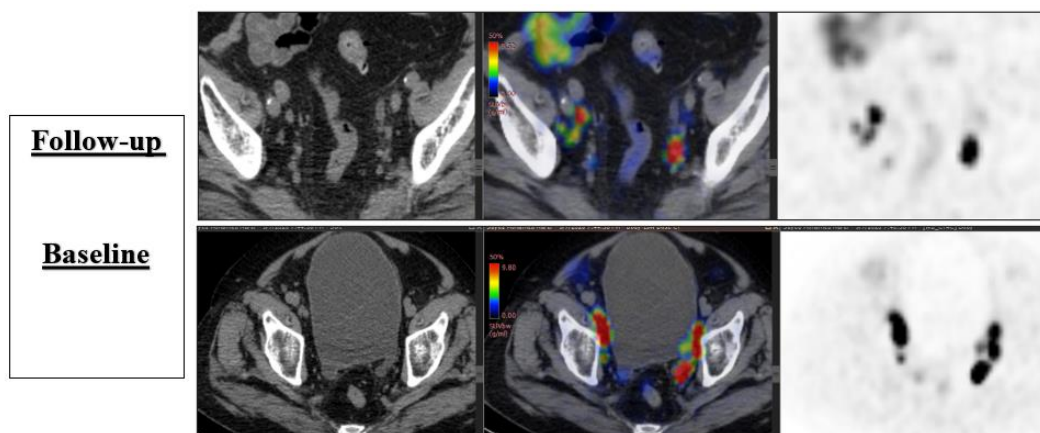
post-therapy PSMA-PET/CT study showing non-progressive TL-PSMA response and SUV max (partial response) of pelvic lymph nodes of case1.
